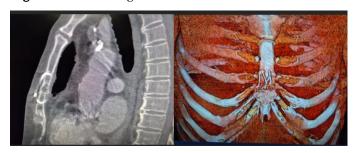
Sternal alignment evaluated in chest CT
